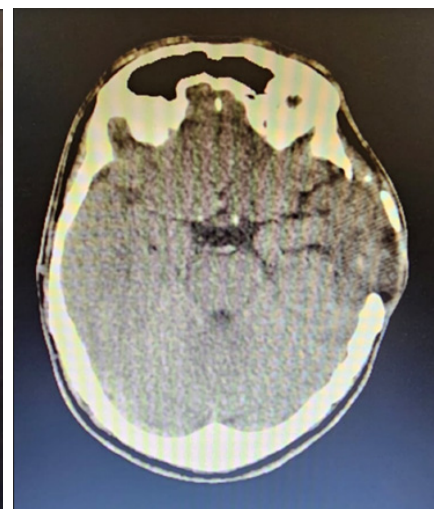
Postoperative axial non-contrast brain computed tomography demonstrating expected post-surgical changes, including a left frontoparietal-temporal craniectomy defect, residual perilesional edema, and a mild rightward midline shift (2–3 mm). No new focal abnormalities are identified, and the cerebellum, brainstem, basal ganglia, and thalami appear unremarkable.
